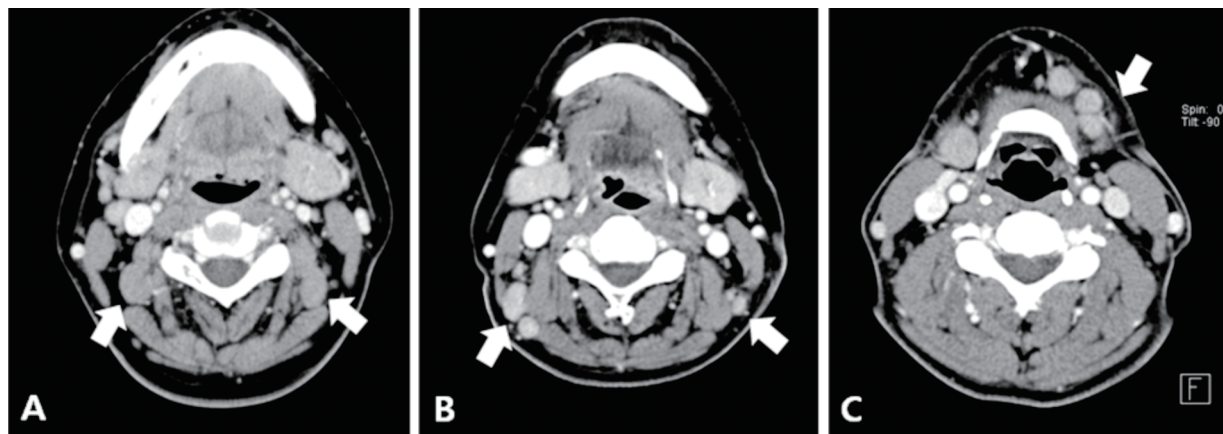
Neck computed tomography of the toxoplasmosis patients show multiple enlarged lymph nodes (arrows). A: Multiple enlarged lymph nodes are present at both level II region (Case 2). B: The CT revealed round to oval enlarged lymph nodes at both level II area (case 3). C: There are three left submandibular enlarged lymph nodes (Case 4).
